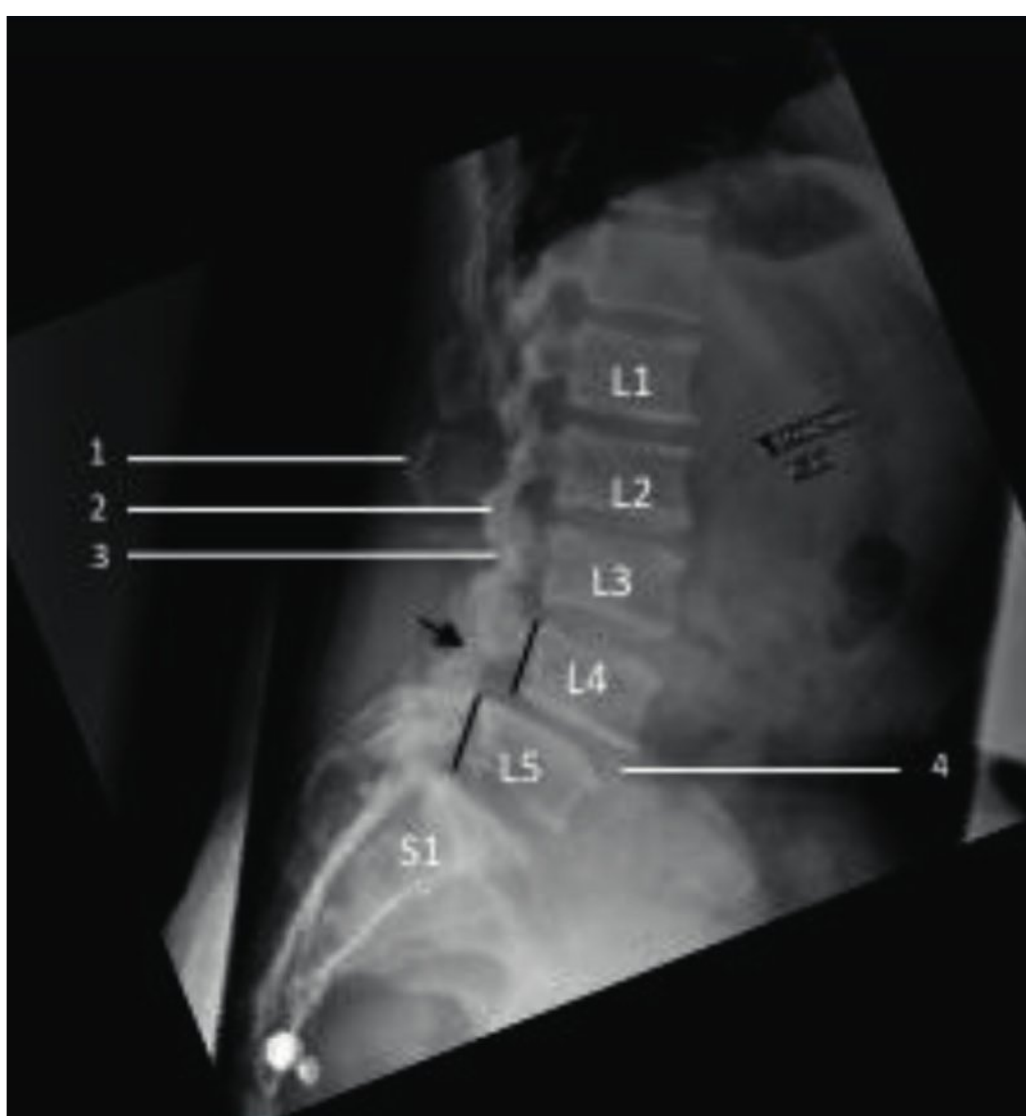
Lateral plain film radiograph (flexion). 1, L2 spinous process; 2, L2 inferior articular process; 3, L3 superior articular process; 4, L4–L5 slip (anterolisthesis); arrow, pars defect.
